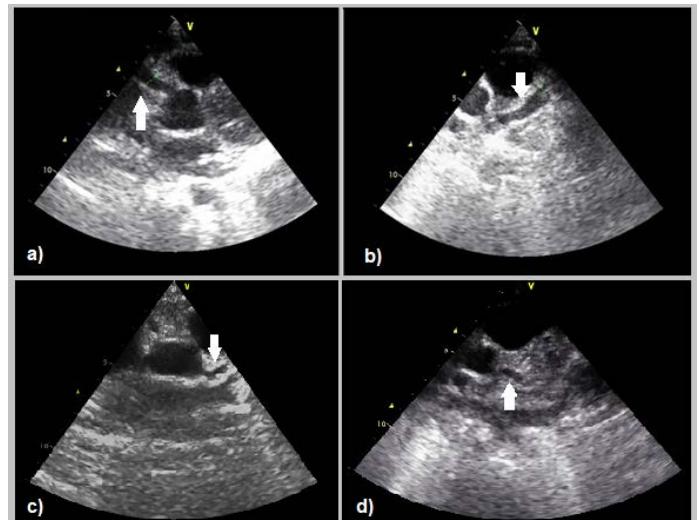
Parasternal short axis view of echocardiogram showing: (A) Right coronary artery measuring about 6 mm (Z-score of +9.7); (B) Left anterior descending artery of 7 mm (Z-score of +13); (C) Left coronary artery and bifurcation; (D) Circumflex artery measuring around 3.8 mm (Z-score of +2.7).
